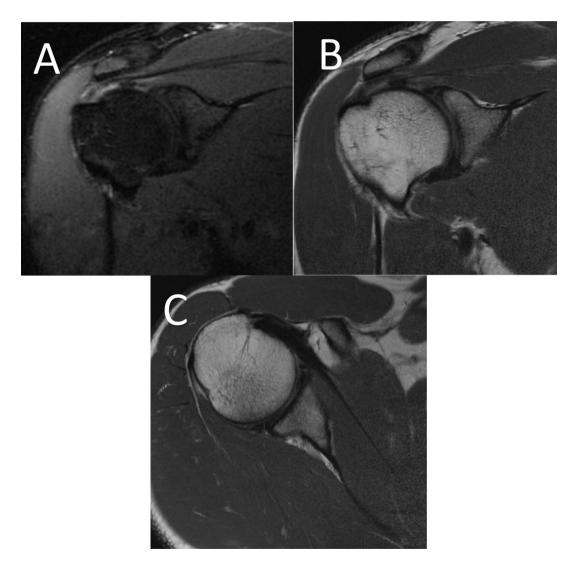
MRI of 40-year-old minor league baseball pitcher with internal impingement A. Coronal Inversion Recovery image demonstrates partial articular sided supraspinatus tear. B. Coronal proton density
